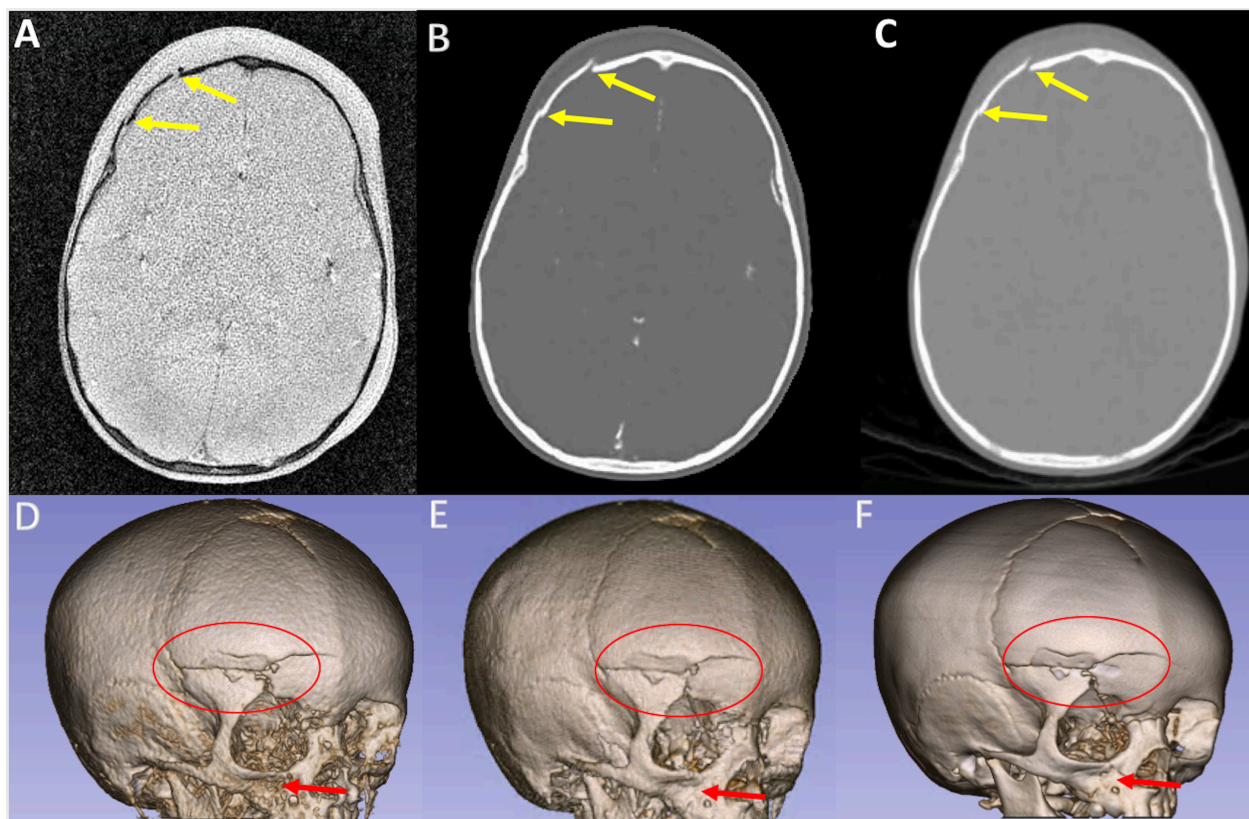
Example MR (A), pCT<sub>Com</sub> (B), and CT (C) images from a trauma patient (1.6-year-old, female) with fractures marked by yellow arrows, and the corresponding 3D surface rendered cranial bone images of iMR (D), pCT<sub>Com</sub> (E), and CT (F). A fracture is marked by a red circle. The
